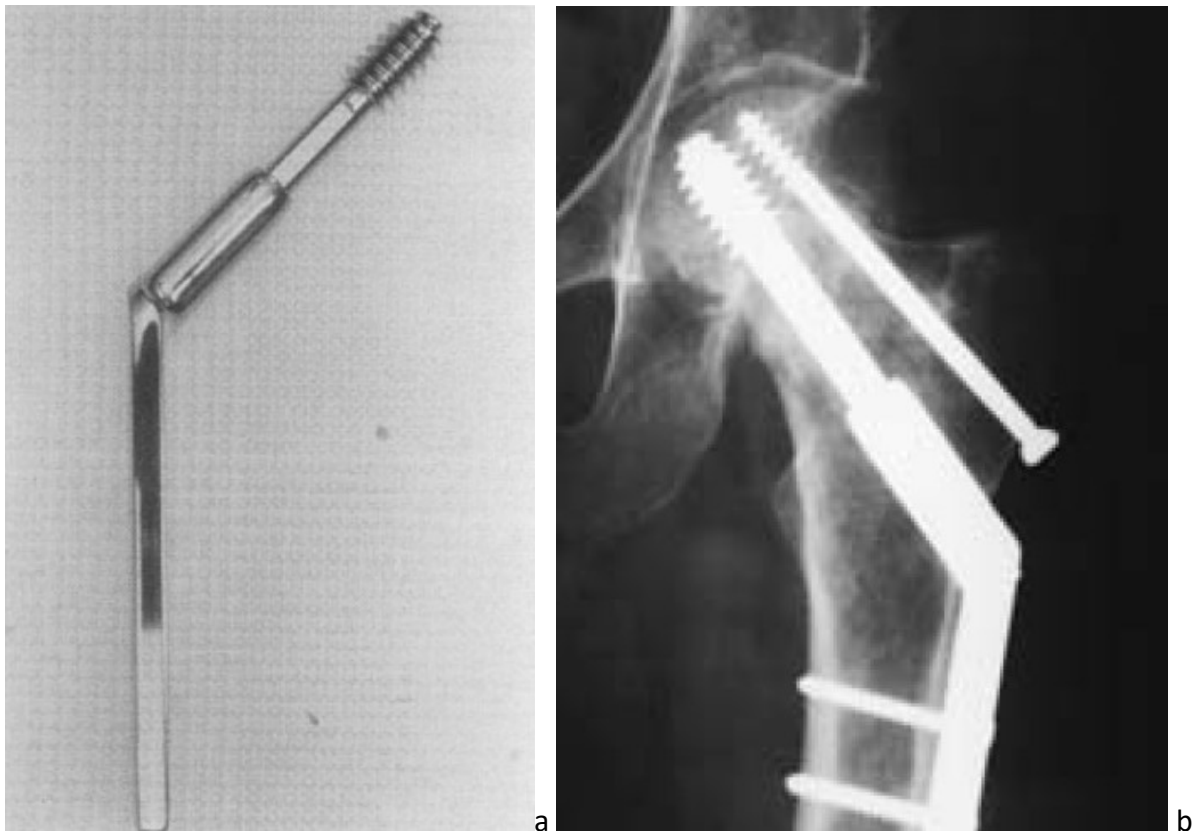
Photograph of a dynamic hip screw (a) and radiograph of implanted dynamic hip screw with an additional screw to help resist femoral head rotation (b) Reproduced with permission from Springer (licence number: a. 4450960195677, b. 4450941404121); (a. [14], b[9]).
